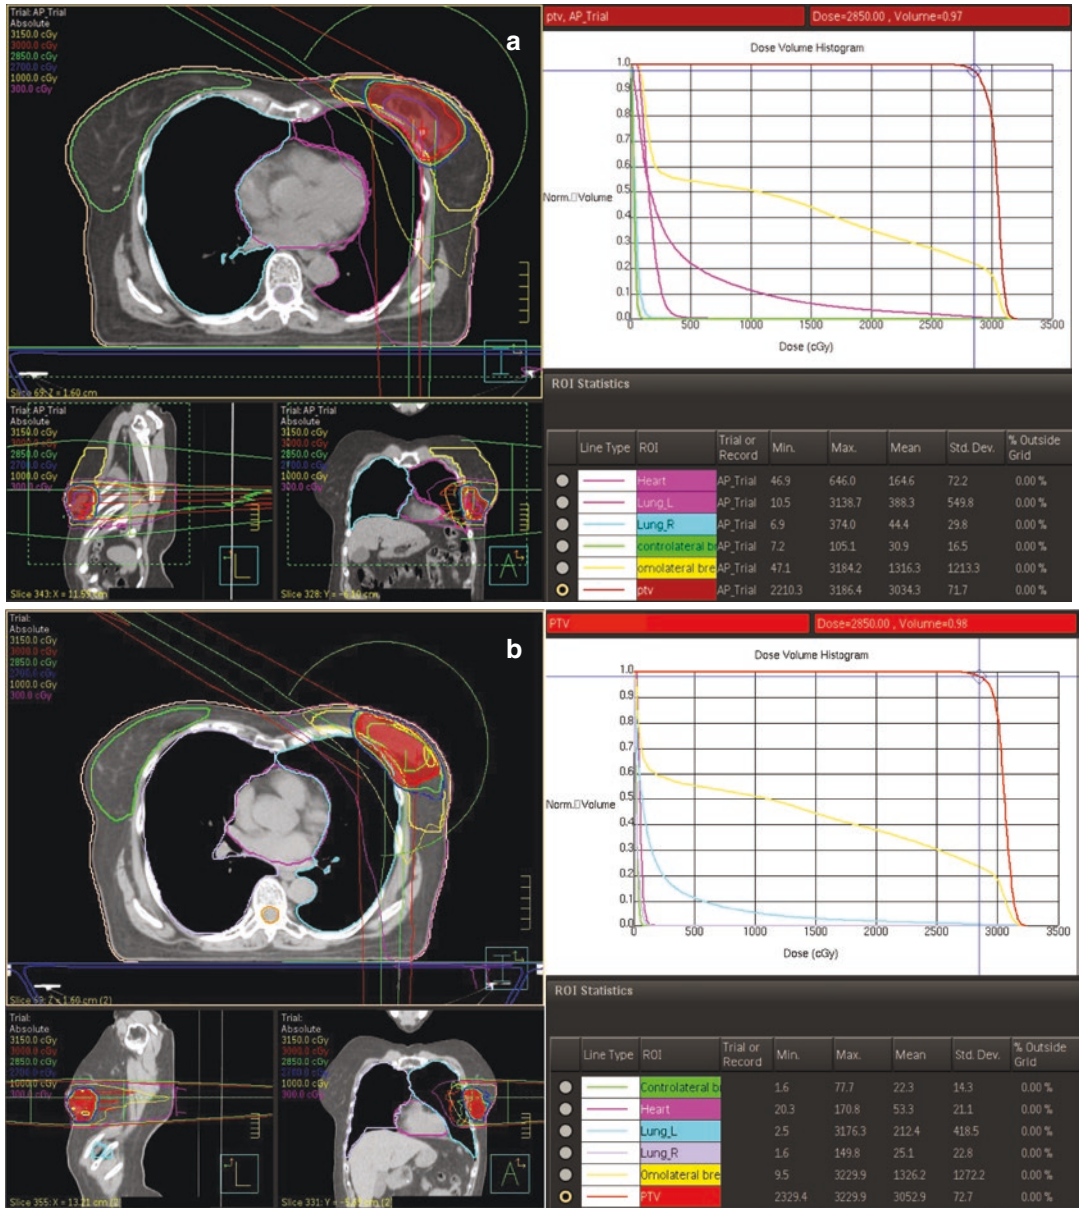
Dose distributions and DVHs for an APBI VMAT treatment (30 Gy in 5 fractions) with a partial arc taken from the FLORENCE APBI trial [NCT02104895]. In (a) the treatment is planned on a free-breathing CT
